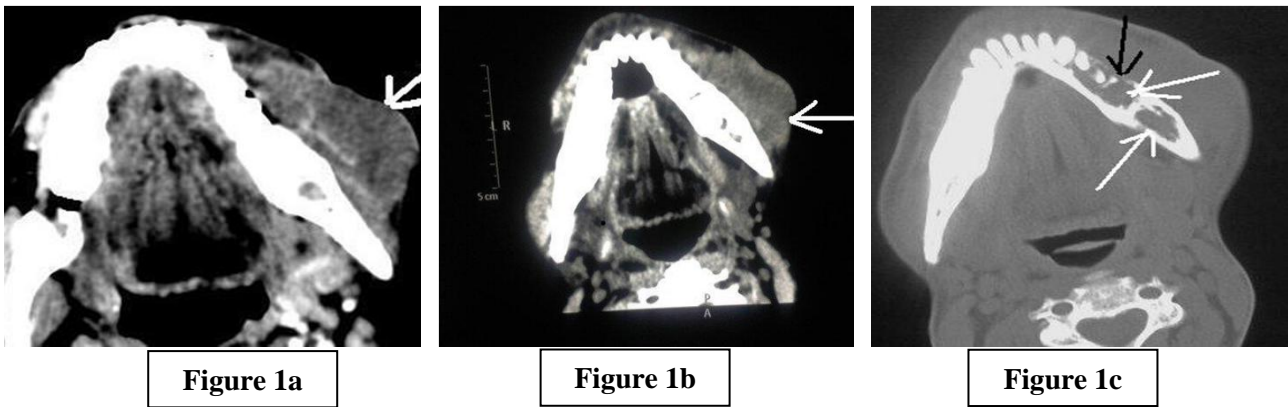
Contrast enhanced CT scan axial section of mandibular region. Figure 1a and 1b - soft tissue swelling in soft tissue window shows the underlying pathology of heterogeneous density with mild enhancement on left side (white arrows). Figure 1c - Bone window shows lytic destructive lesion (white arrows) and loosening of corresponding teeth (black arrow).
